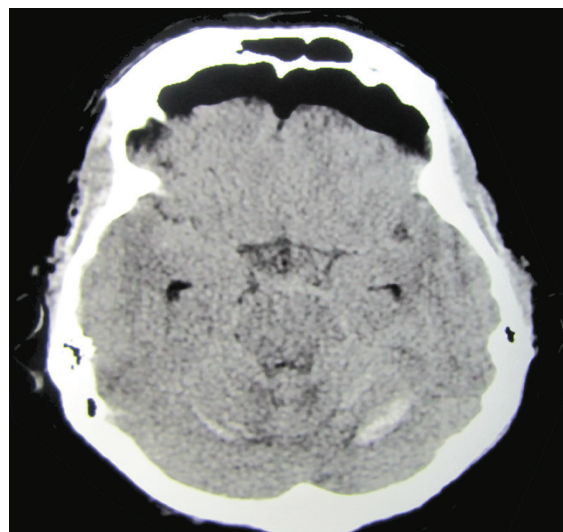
Postoperative CT scan: bifrontal pneumocephalus and hemorrhage within both cerebellar hemispheres, the lesion on the left side being larger.
